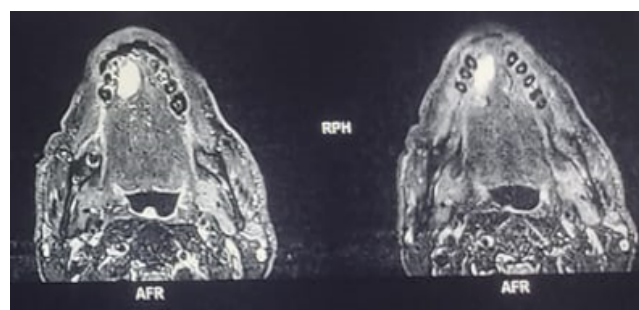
T2- weighted MRI appearance of the VM depicted. the malformation appears hyperintense.
